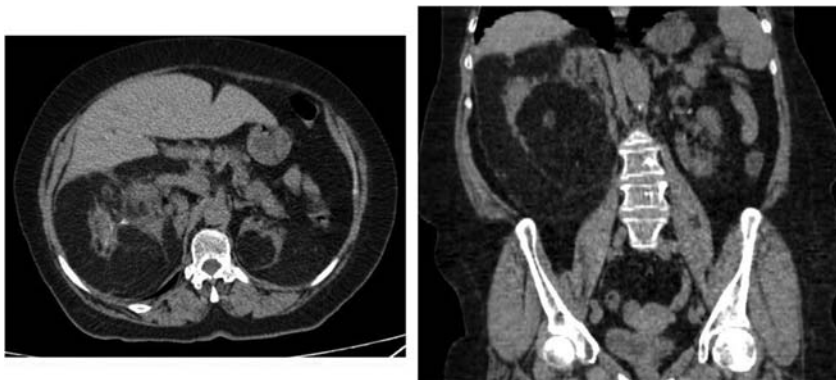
Axial and reformatted coronal abdominal computed tomography images of renal angiomyolipomas.
